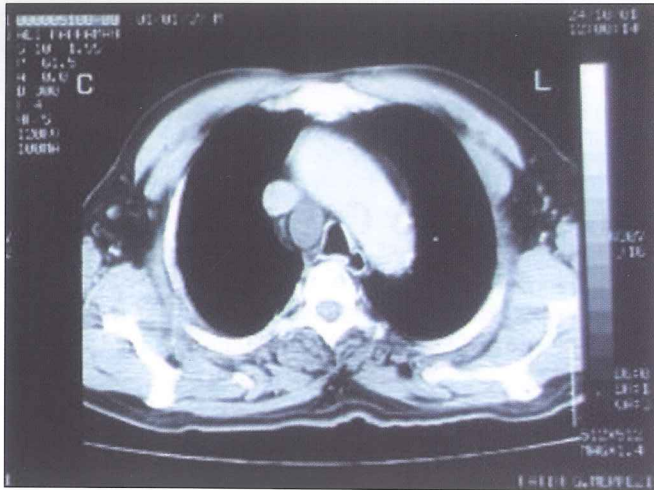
Thorax computed tomography of Case 1, depicting the cystic nature of the mass and location in the paratracheal region.
